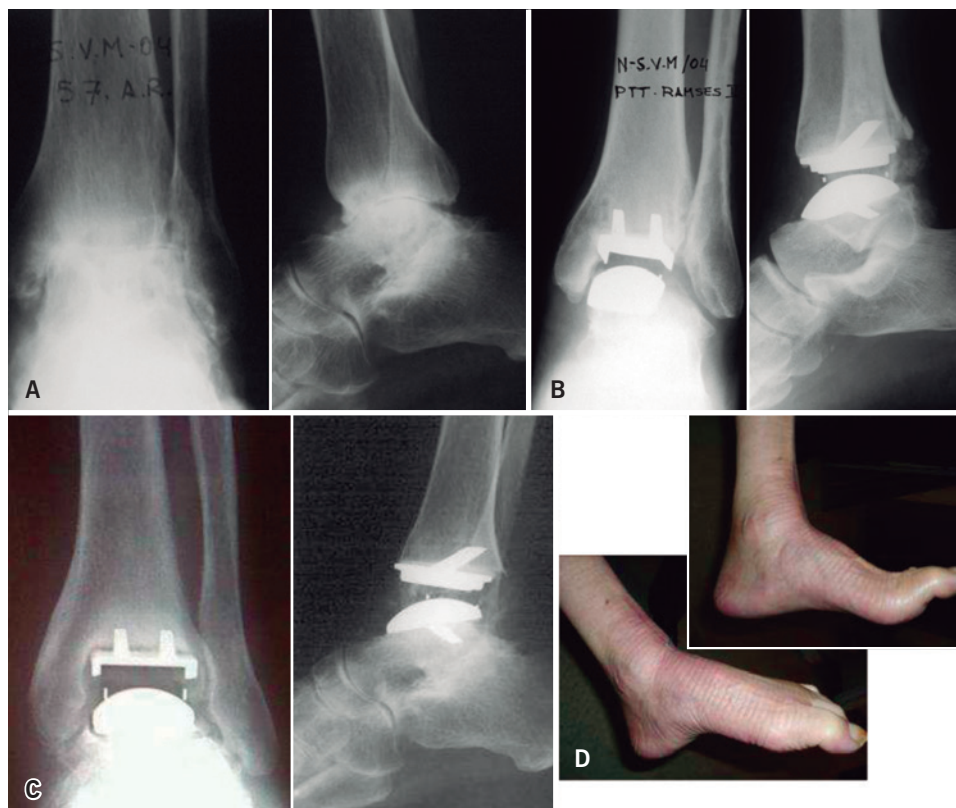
Male, 48 years old. Squeals of ankle fracture dislocation at 18 years of age Ramses II TAR in 2003. Last clinic 2003, at 10 years follow up, occasional pain. Normal daily living. Sports with limitations; A) Pre-op X-ray; B) Post-operative X-ray; C) X-ray at 10 years, peri-implant radiolucent images asymptomatic
